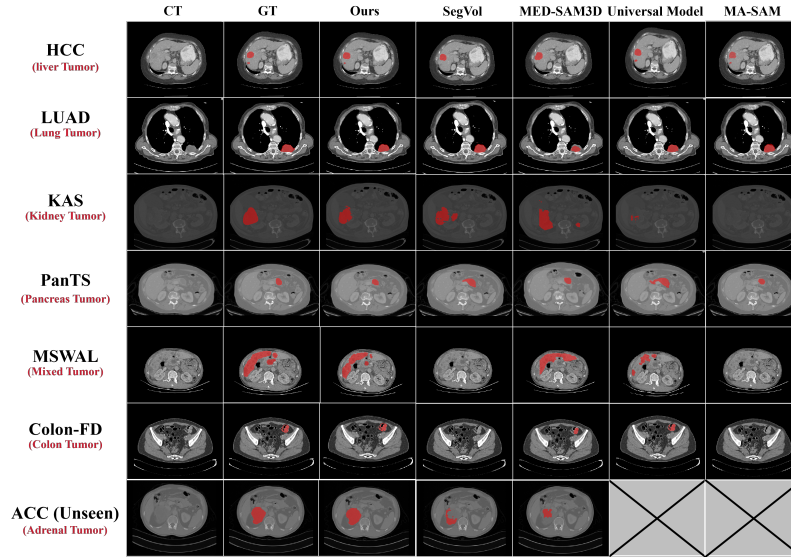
Qualitative comparisons of the proposed ECLIPSE (Ours) with other methods for multi-tumor segmentation. Each row represents one type of tumor. Column 1 shows the original CT scans, column 2 presents the ground-truth segmentation, and columns 3-7 show the predictions from different SOTA methods.
